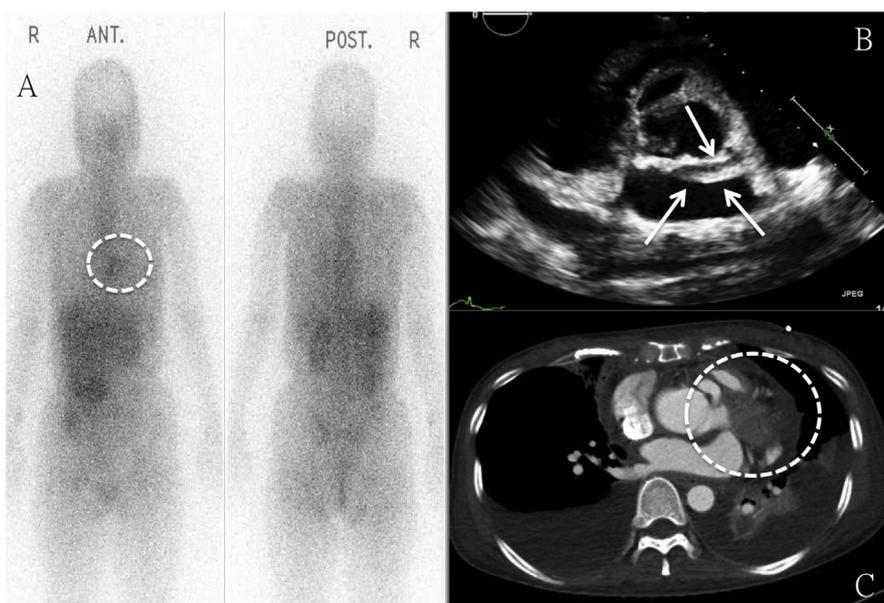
The image findings of a 55-year-old female with aortic valve endocarditis and perivalvular abscess due to nontyphoid *Salmonella*. (A) The inflammation scan shows inflammation around the upper heart (dotted circle). (B) The transesophageal echo shows the bicuspid aortic valve and a perivalvular abscess with a length of approximately two-thirds the aortic root diameter (arrows). (C) Cardiac computed tomography shows periaortic leakage or abscess near the right ventricular outflow tract (dotted circle).
